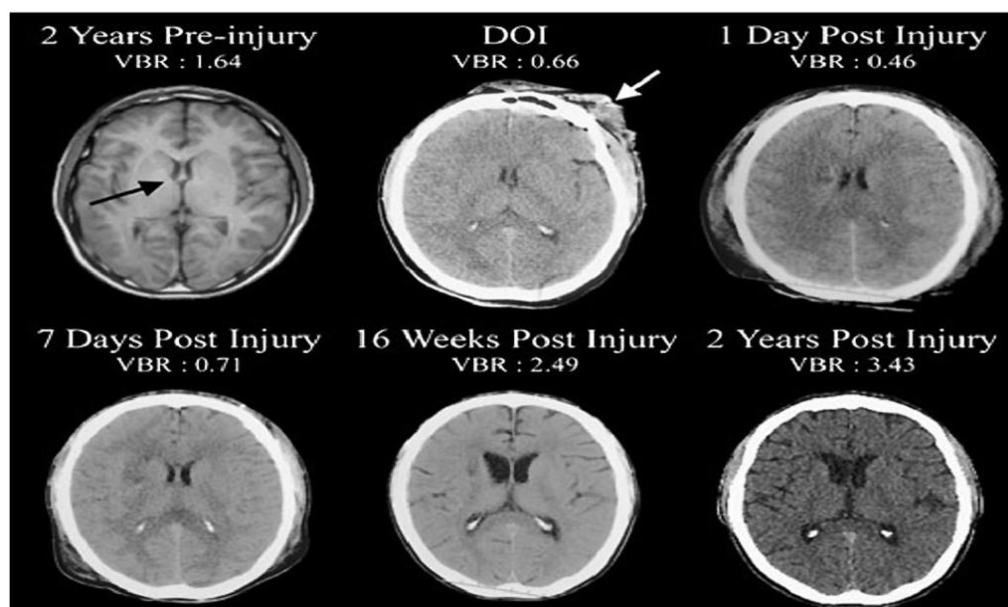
Two years prior to sustaining a severe traumatic brain injury (TBI) this patient underwent magnetic resonance imaging (MRI) as part of an assessment for persistent headache. The MRI was interpreted as within normal limits (WNL) and computation of the ventricle-to-brain ratio (VBR) was likewise WNL (average adult VBR is ~1.5 with a 0.5 standard deviation based on total ventricular volume/total brain volume multiplied by 100 so that whole numbers may be used) ⁽³⁾.
